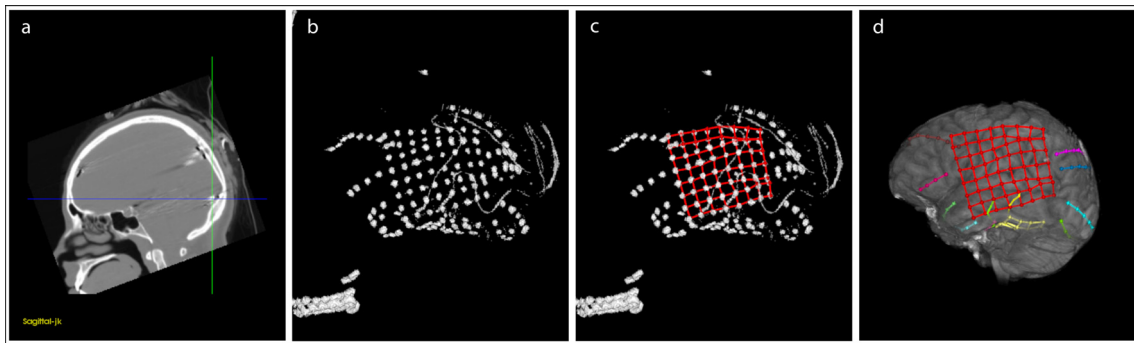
a) Saggital slice of a thin slice CT scan of a patient with implanted intracranial electrodes. b) 3D reconstruction of the same patient’s CT scan, thresholded at the maximum intensity of the artifact caused by the metal of the electrode contacts. c) Using the interface of Bioimagesuite we manually associate every contact with a virtual electrode, which will bear the same coordinates as the real one. d) Electrodes can be overlaid on any 3D imaging of the patient which is co-registered to the same MNI standard space. Different grid and strip electrodes are individually color coded to aid visualization. The electrode localization interface of Bioimagesuite allows to rotate and cut the actual 3D volume in any direction.
